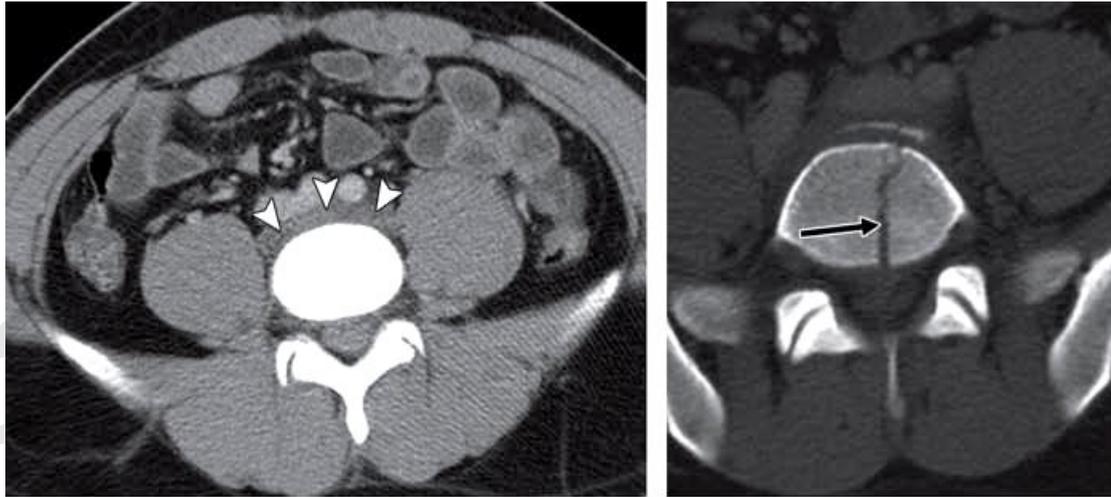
Abdominal CT scan with IV contrast (Small zone I retroperitoneal hematoma) shows a small amount of intermediate-attenuation fluid (arrowheads) between the aorta and IVC, the finding represents venous hemorrhage. ⁽⁷³⁾
